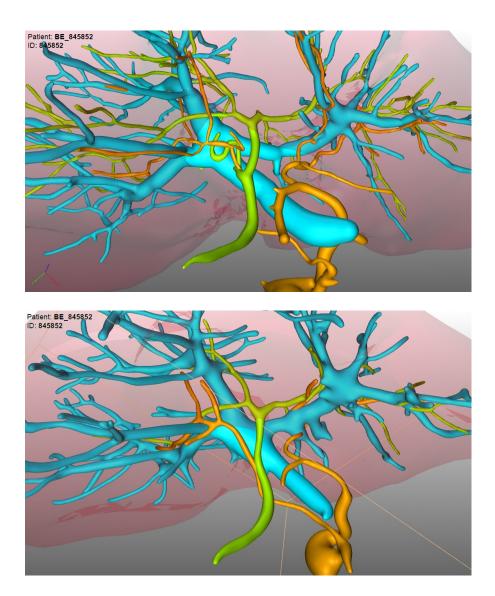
Vascular structures extracted from CT (top) and MRI (below) data of the same donor candidate. The topology of portal vein (cyan), hepatic artery (orange) and bile ducts (green) is comparable with a few more details visible in the CT-based results.
